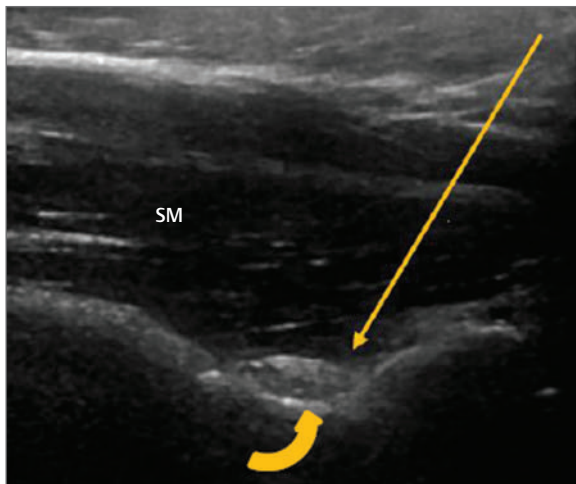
Ultrasound image of the supraspinous fossa and supraspinatus muscle (SM). The supraspinatus notch may be seen deep to the supraspinatus muscle. The suprascapular nerve appears as an echogenic oval structure within the suprascapular notch (*curved arrow*). The needle is directed toward the suprascapular nerve as indicated by the straight arrow. Straight arrow, direction of the needle.
